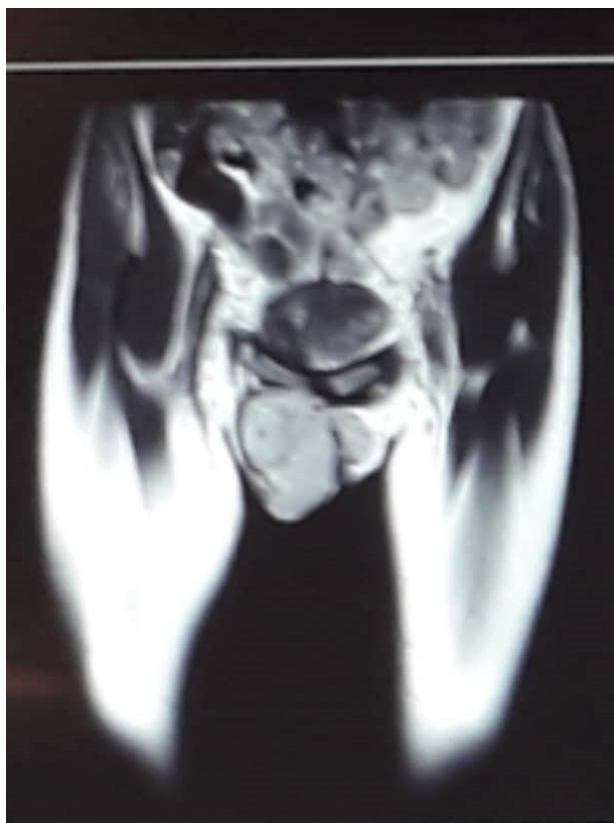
Magnetic resonance imaging (MRI) of the tumor
